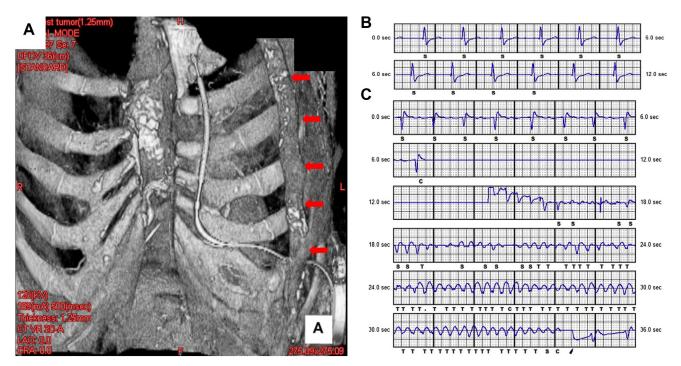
A: Postoperative plain computed tomography scan image confirming the lead placed on the edge of the ribs without sticking into the omental flap as shown by the red arrow. B: Electrogram tracing from the substernal lead showing an appropriate R-wave amplitude in all of the 3 vectors. C: Successful defibrillation test performed with a single 65 J shock after ventricular fibrillation induction with a 50 Hz stimulation.
